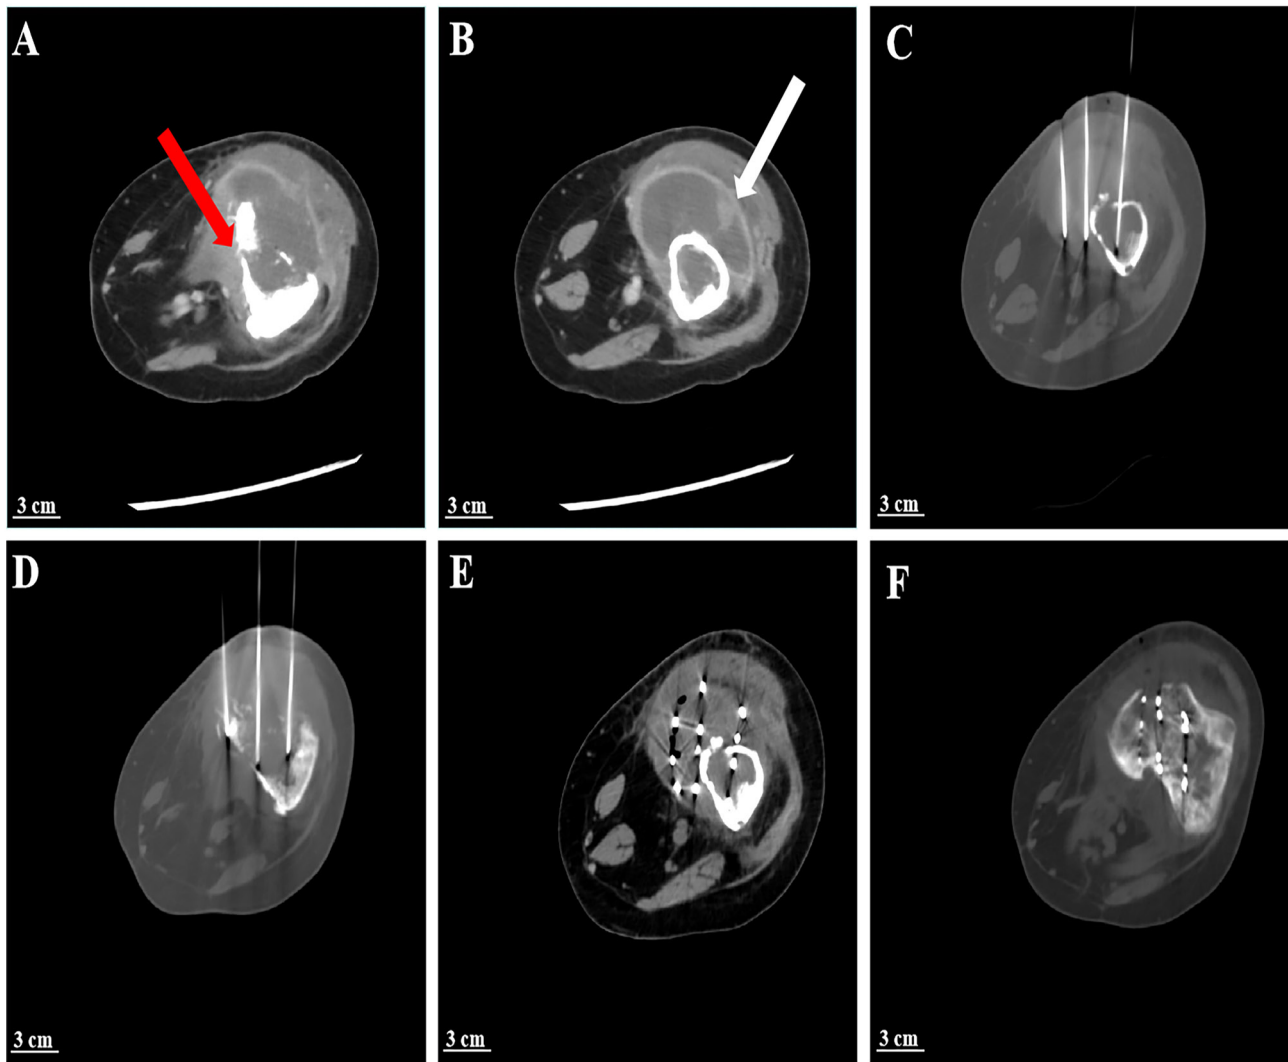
After two TACE treatments, enhanced CT follow-up images and process of iodine-125 seed implantation. (A) A notable reduction in tumor blood supply was detected; the red arrow points to the area of bone destruction in the lower part of the left femur, surrounded by mostly necrotic tumor tissue. (B) The white arrow points to the non-enhanced necrotic tumor tissue around the middle part of the left femur, and a decrease in the maximum tumor diameter was detected. (C) Using an 18 G puncture needle, the tumor was penetrated horizontally through the middle sections of the left femur. (D) Using an 18 G puncture needle, the tumor was penetrated horizontally through the left lower femur at the level of the proximal articular surface. (E) Following the successful insertion of iodine-125 seeds, a real-time CT scan was conducted to confirm their optimal distribution within the tumor located in the middle sections of the left femur. (F) Following the successful insertion of iodine-125 seeds, a real-time CT scan was conducted to confirm their optimal distribution within the tumor located on the proximal articular surface of the left lower femoral segment.
